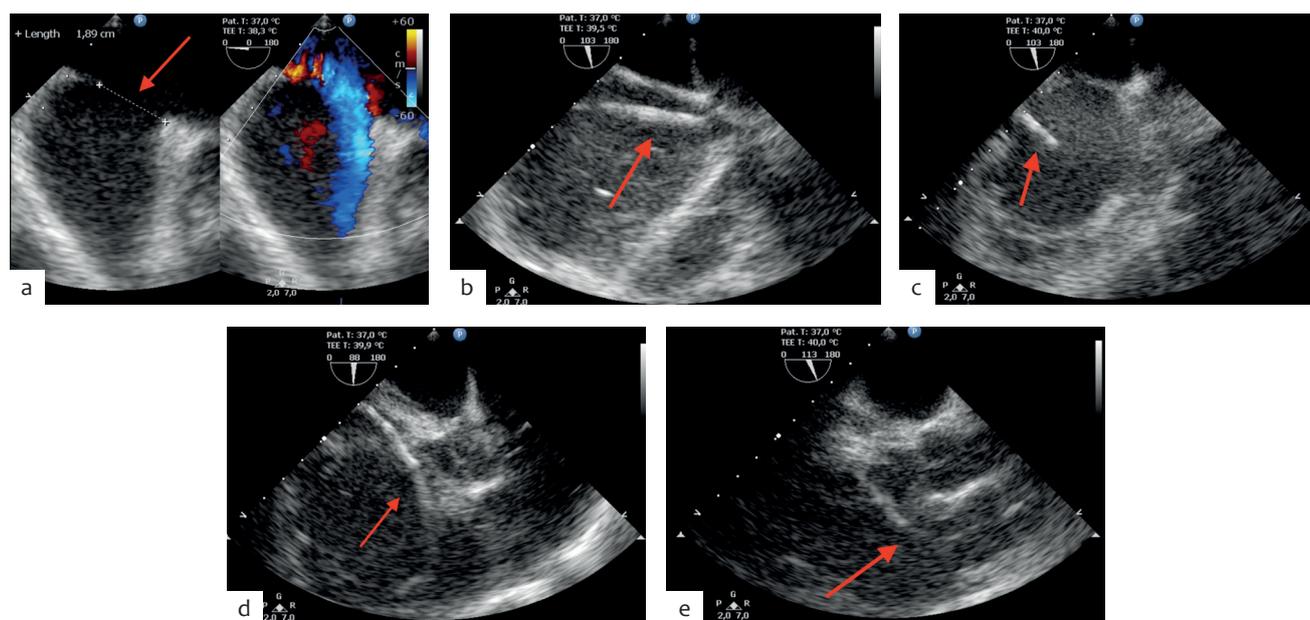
Diagnostic catheterization under TEE guidance (red arrow). (a) Pre-procedural TEE showed the diameter of the secundum ASD; (b) visualization of MP catheter at SVC; (c) visualization of MP catheter at RA; (d) MP catheter was placed at RVOT; (e) visualization of MP catheter at MPA. TEE=transesophageal echocardiography; ASD=atrial septal defect; MP=multipurpose; SVC=superior vena cava; RA=right atrium; RVOT=right ventricular outflow tract; MPA=main pulmonary artery
